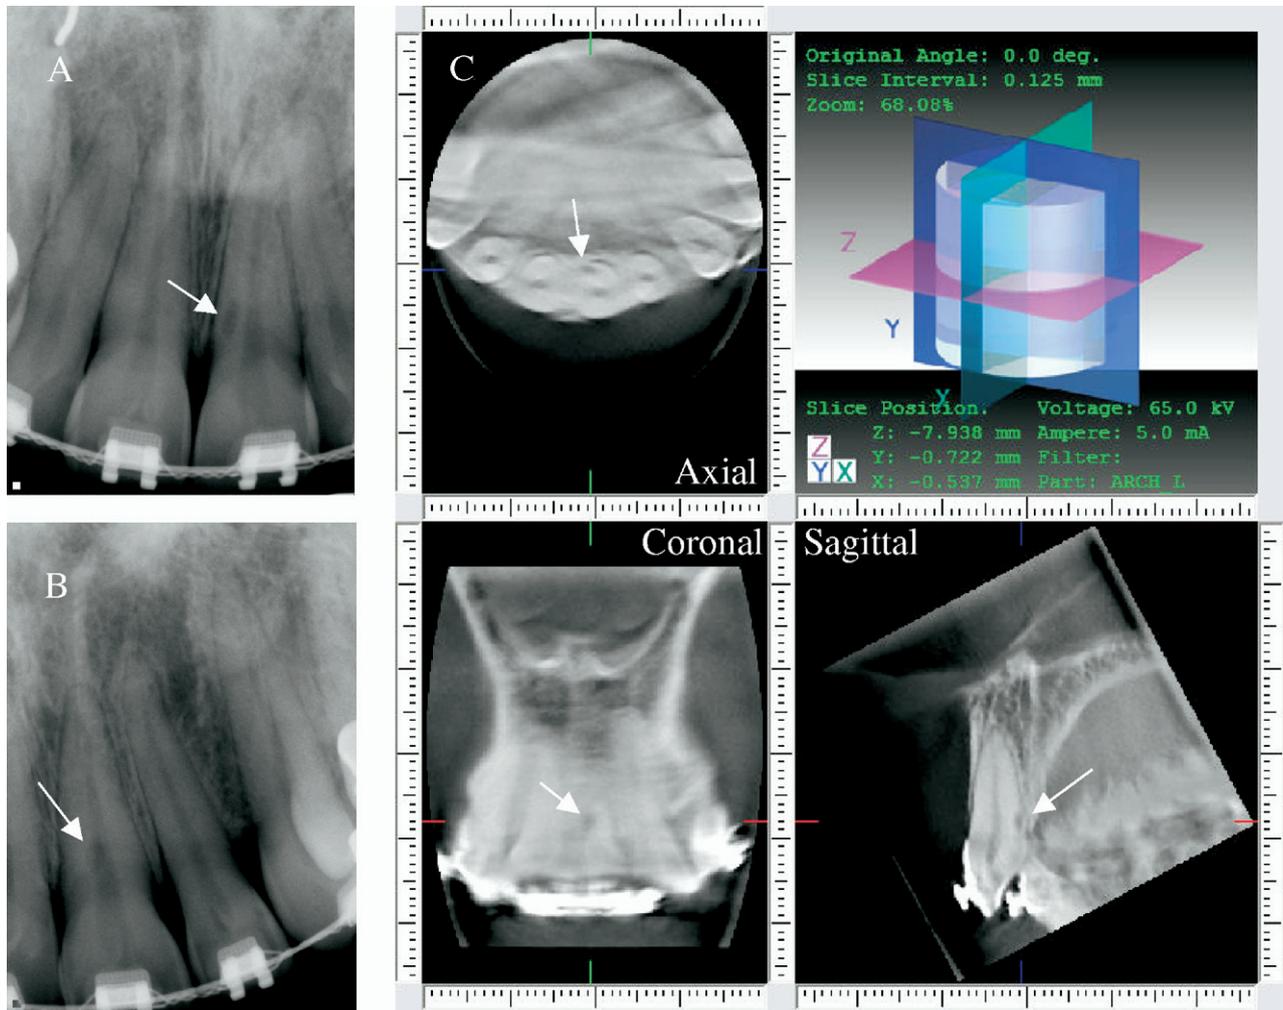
(A) Periapical radiograph demonstrates a radiolucent lesion in the cervical third of root #9. (B) Periapical radiograph exposed from a distal angulation shows the radiolucency superimposed over the canal, indicating a lingually positioned lesion. (C) CBVT demonstrates the axial, sagittal, and coronal 2-D slices of the Heathersay Class 2 ICR, located mesiolingually on tooth #9.
